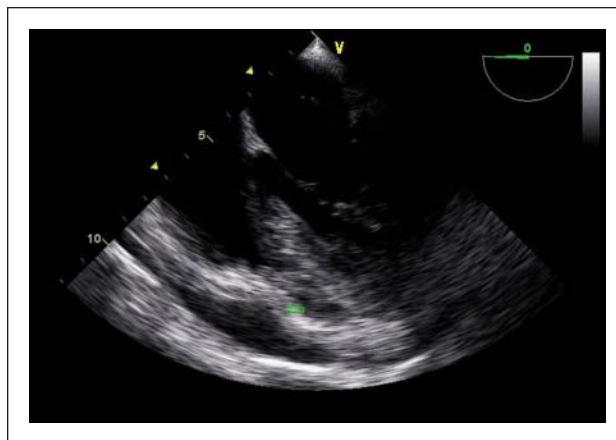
Mid-esophageal 4-chamber transesophageal echocardiography view of a pericardial effusion. Diastolic right ventricular collapse (arrow) is a sensitive sign of cardiac tamponade
